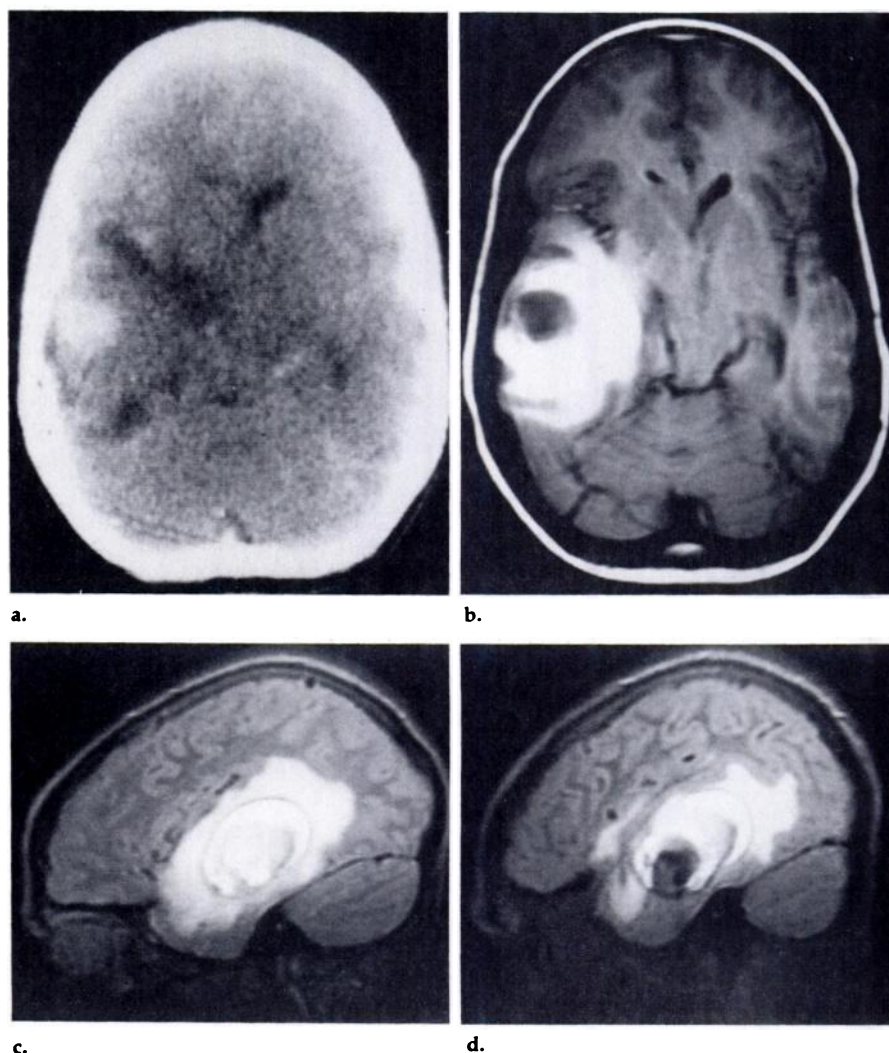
Small right temporal arteriovenous malformation and associated recent and aging ICHs in a 13-year-old boy. (a) Unenhanced CT scan within 2 days after occurrence of ICH. Recent hyperdense hematoma is surrounded by aging isodense hematoma. (b) Axial T1-WI (TR, 800 msec; TE, 20 msec). There is a large hyperintense region in the right temporal lobe with central hypointensity, slightly less intense than gray matter. These correspond to the isodense and hyperdense ICHs shown by CT. (c) Sagittal T2-WI through medial right temporal lobe (TR, 1,500 msec; TE, 40 msec). There is a moderately intense perihematoma edema and a ring of hypointensity surrounding a smaller ring of marked hyperintensity and an isointense center. (d) Sagittal T2-WI of the lateral portion of the right temporal lobe (TR, 1,500 msec; TE, 40 msec). Hypointense center of recent hematoma is surrounded by an edema-like intensity, probably due to some fluid collection.
